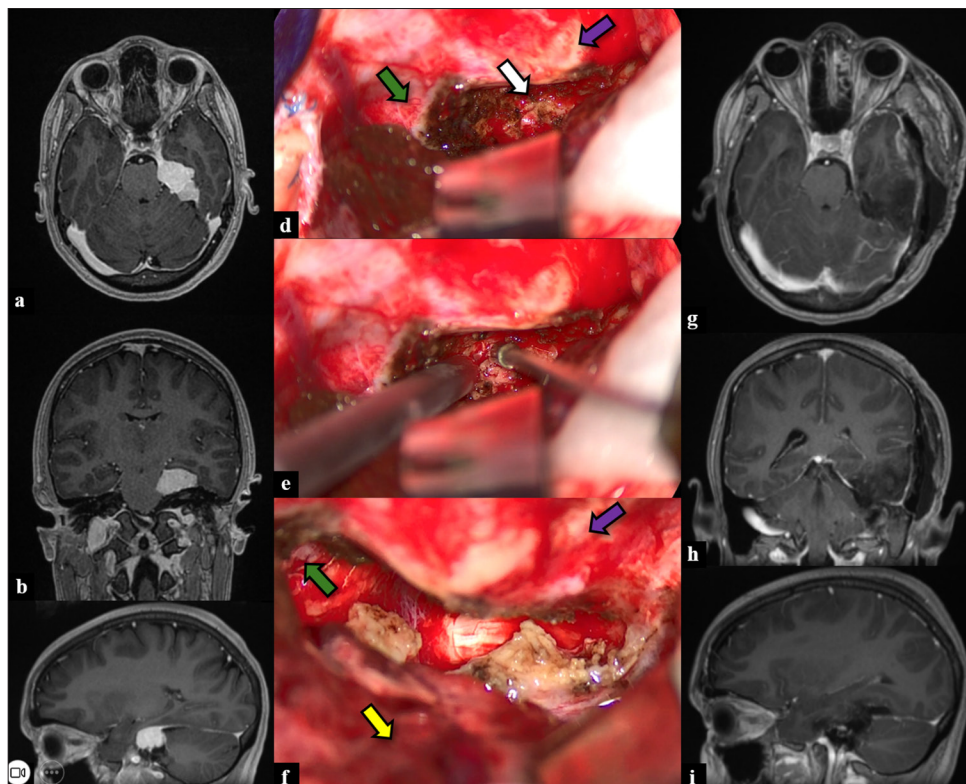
(a-c) Axial (a), coronal (b), and sagittal (c) views of the postcontrast T1-weighted sequence of the initial brain magnetic resonance imaging (MRI), revealing an extra-axial lesion located in the petrous ridge and tentorium cerebelli at the left side. (d-f) Images retrieved from the second surgical treatment. (d) The recurrent tumor (pointed by the white arrow) was located from the petrous ridge to the tentorial notch (pointed by the green arrow). The purple arrow points to the petrous part of the temporal bone. (e) The resection of the recurrent tumor was performed using the same previous approach, which included the resection of the inferior temporal gyrus. (f) The final aspect is after the tumor resection and the dural coagulation. The tentorial notch (pointed by the green arrow), the petrous part of the temporal bone (pointed by the purple arrow), and the left temporal lobe (pointed by the yellow arrow) are demonstrated. (g-i) Axial (g), coronal (h), and sagittal (i) views of the postcontrast T1-weighted sequence of brain MRI performed after the second surgical treatment evidenced no other tumoral recurrence.
